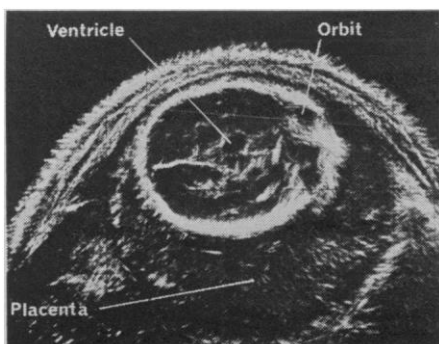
Transverse scan of the uterus of a pregnant woman that shows the fetal head and the location of the placenta. The orbit, the bony structure that encases the eye, and the brain ventricles can be seen in the fetal skull. The scan is a two-dimensional scan in the B (brightness) mode. In this mode, the ultrasound echoes are displayed as a series of dots on an oscilloscope screen, with the brightness of the dots determined by the intensity of the echoes. A two-dimensional image can be built by moving the probe over the body surface and recording the echoes on a storage oscilloscope. [Source: G. Kossoff, National Acoustics Laboratory, Sydney, Australia]
